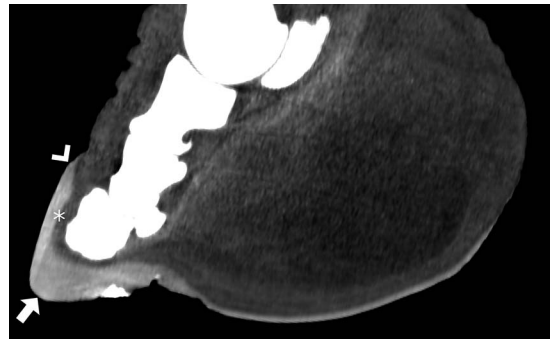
A sagittal computed tomography image in a soft-tissue window demonstrating the tapered appearance of the hoof wall in a greater one-horned rhinoceros (*Rhinoceros unicornis*). The hoof wall is hyperattenuating to the underlying sensitive laminae (asterisk) and thickest at the toe (arrow), tapering significantly over the region of the coronary band (chevron).
